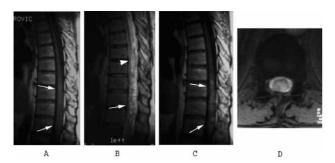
Magnetic resonance (MR) imaging of a 40-year old man with thoracic spinal cord sarcoidosis, eight months after first onset of neurological symptoms. A) T1-weighted image in the sagittal plane shows thickened portion of the thoracic spinal cord (white arrows). B) T2-weighted image in the sagittal plane reveals inhomogenously increased signal in the thickened portion of the cord (white arrow), along with cord edema extending proximally (white arrowhead). C) T1-weighted image in the sagittal plane after application of gadolinium demonstrates dense inhomogenous enhancement, corresponding to the areas of increased signal intensity on T2-weighted images (white arrows). D) Gradient-echo T2-weighted image in the axial plane demonstrates thickened spinal cord, with abnormal high signal intensity affecting most of the cord.
